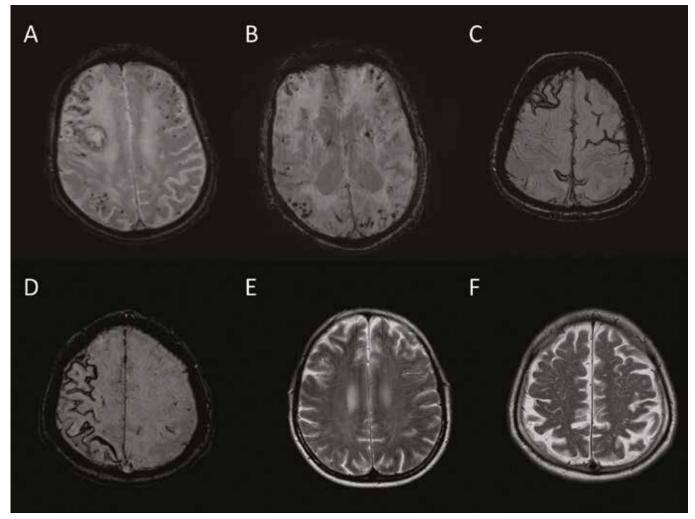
Commonly encountered MRI markers in CAA. Examples of lobar MBs (A, B), cSS (C, D), and CSO-PVS (E,F).
